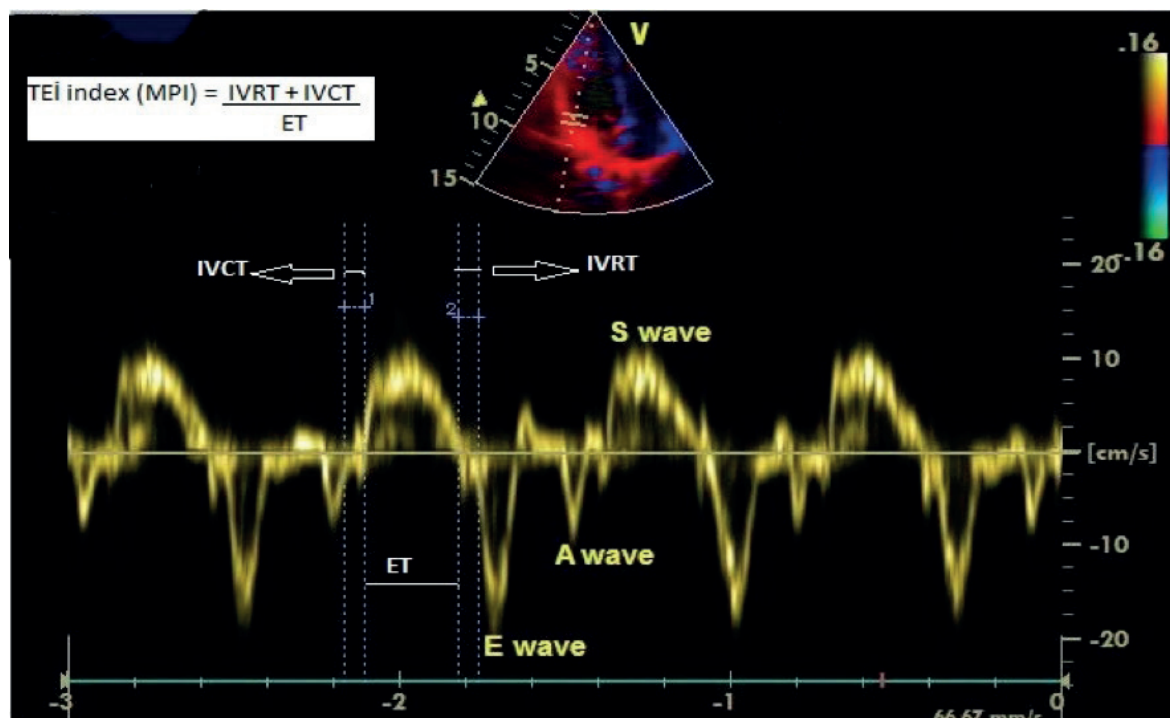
Calculation of left ventricular MPI, waves and time intervals with doppler echocardiography. S wave, systolic myocardial velocity; E wave, early diastolic myocardial velocity; A wave, late diastolic myocardial velocity; IVRT, isovolumic relaxation time; IVCT, isovolumic contraction time; ET, ejection time; MPI, myocardial performance index.
